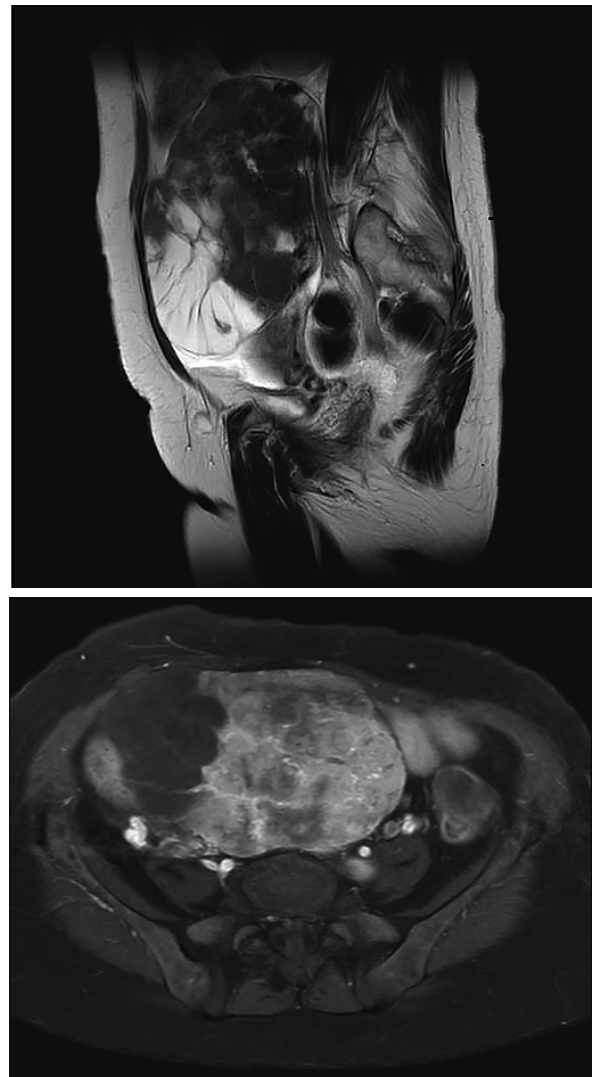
MRI (upper : T2, lower : T1 with Gd enhancement)
